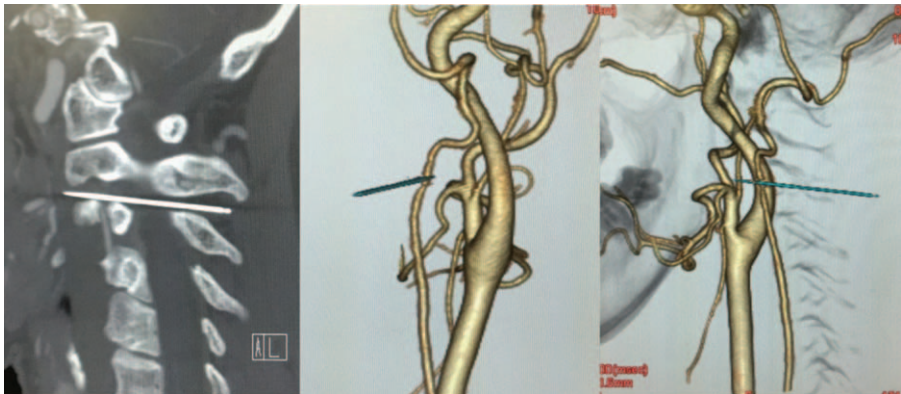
Three-dimensional computed tomography myelograms demonstrating the orientation of the sewing needle from between the C2 and C3 spinous processes to the anterior cervical spine.
